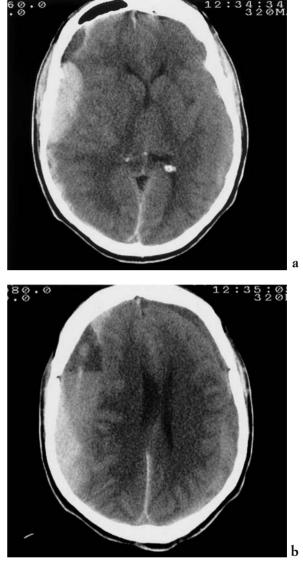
Bilateral subdural haematomas. There is a biloculated acute-subacute subdural haematoma on the right side (a), a heterogeneous appearance of the two haematomas with fluid-fluid levels (b), and presence of haemorrhagic components of different ages. The left sided subacute subdural haematoma is almost isodense as compared to the underlying brain and is therefore somewhat difficult to visualise. [a), b) axial CT].
